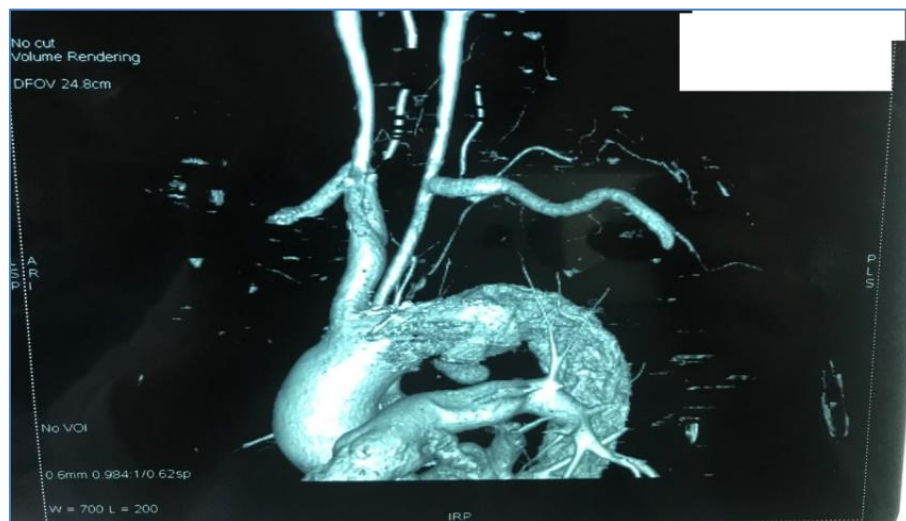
CT angiography of control: exclusion of the false aneurysm, with a permeable carotid-subclavian bypass
